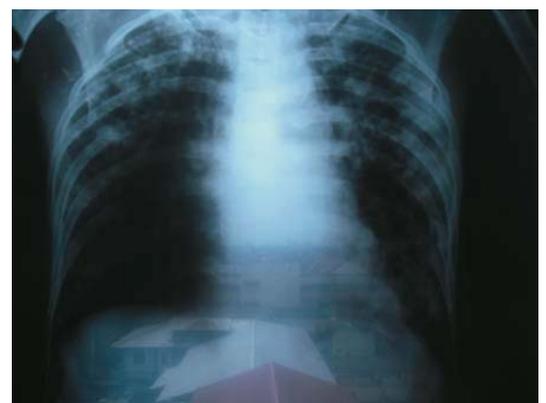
Plain Chest X-ray in posteroanterior view. There were bilateral fibroinfiltrates.
